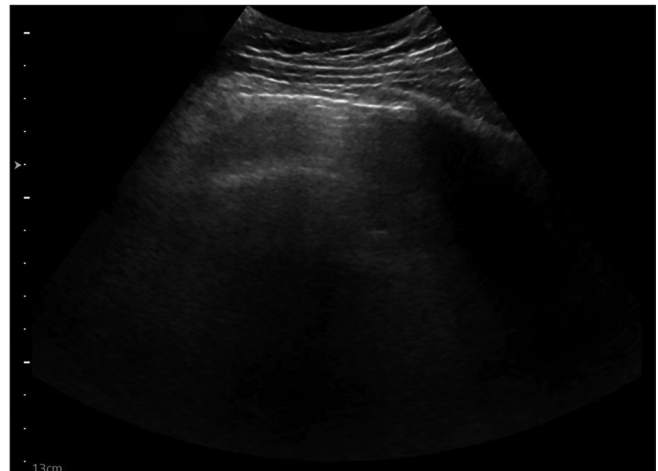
Ultrasound image of the periumbilical region of the abdomen
